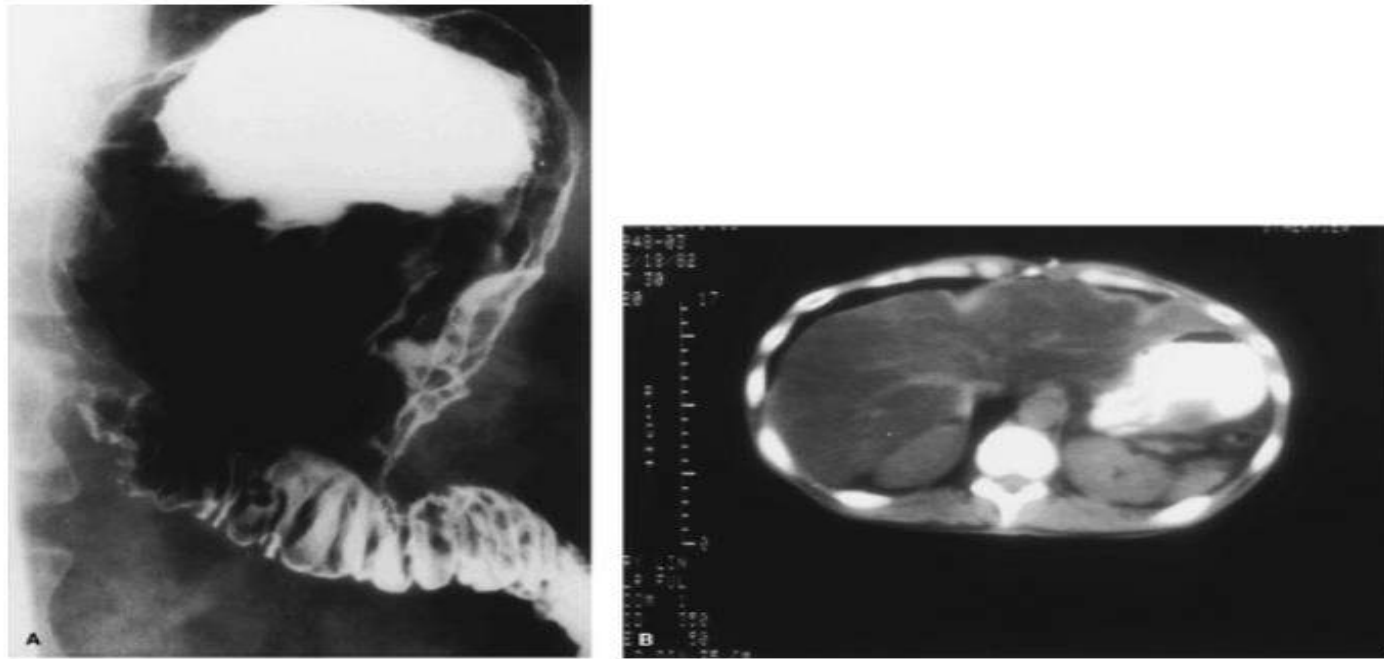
Radiographic visualization of gastric carcinoma after gastrectomy and Billroth II reconstruction. A: Note the irregular mucosal contour of the gastric remnant as seen on barium upper gastrointestinal radiography. B: The tumor is clearly seen on a computed tomographic scan in the posterior gastric wall.
